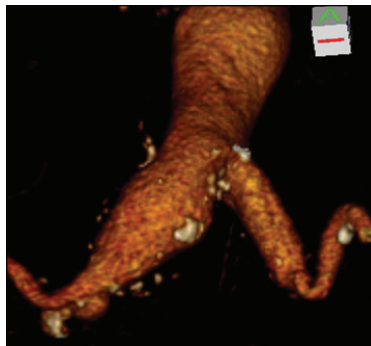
Preprocedural CT scan showing a challenging right common iliac artery aneurysm with a distal lumen that was outside the instructions for use for an off-the-shelf E-iliac device.
